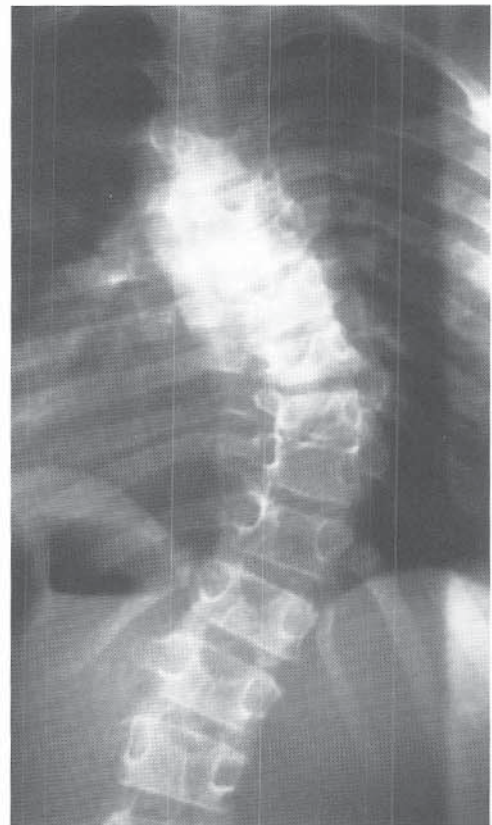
Radiographic appearance of a 10-year-old girl with a 52-degree scoliosis and block vertebrae at T5-6 and T9-10. The deformity cannot be attributed to the mere presence of these abnormalities. MRI of the spinal canal was normal.
